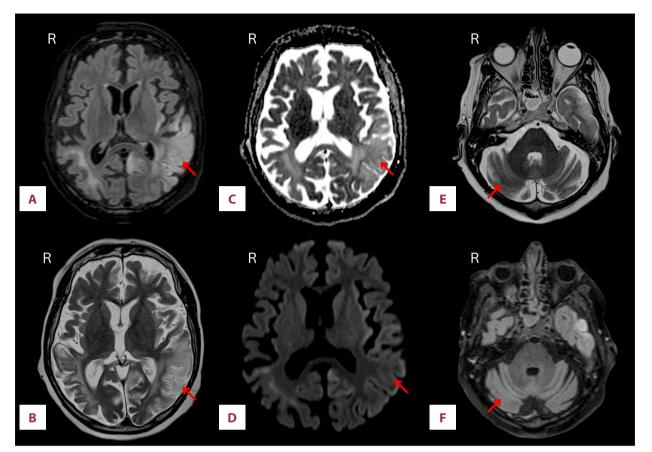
Second axial MRI (A) FLAIR-weighted and (B) T2-weighted showing a partially reversible post-ictal lesion on the left cerebral hemisphere with decreased size and intensity in comparison with the previous MRI. (C) Diffusion-weighted apparent diffusion coefficient (ADC) and (D) diffusion weighted imaging (DWI) revealing increase in ADC values and mimicking the intensity of the previous lesion on the right side and the (E) T2-weighted and (F) FLAIR-weighted of cerebellum with no longer visible right cerebellar lesion.
